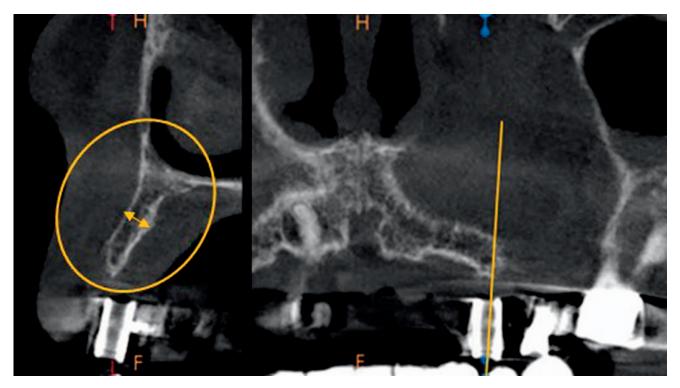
CBCT analysis of the diagnostic guide at site #11 confirms inadequate width of available bone for implant placement at the planned site.
